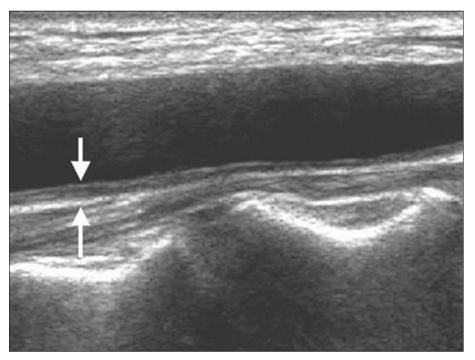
Carotid ultrasonography of a patient with systemic lupus showing increased IMT (IMT =1.1 mm)
